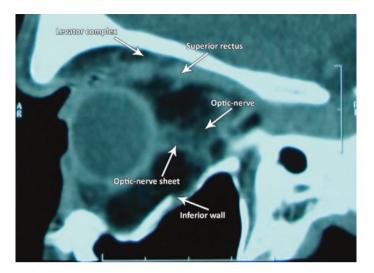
CT-scan in sagittal view imaged at tissue window settings
